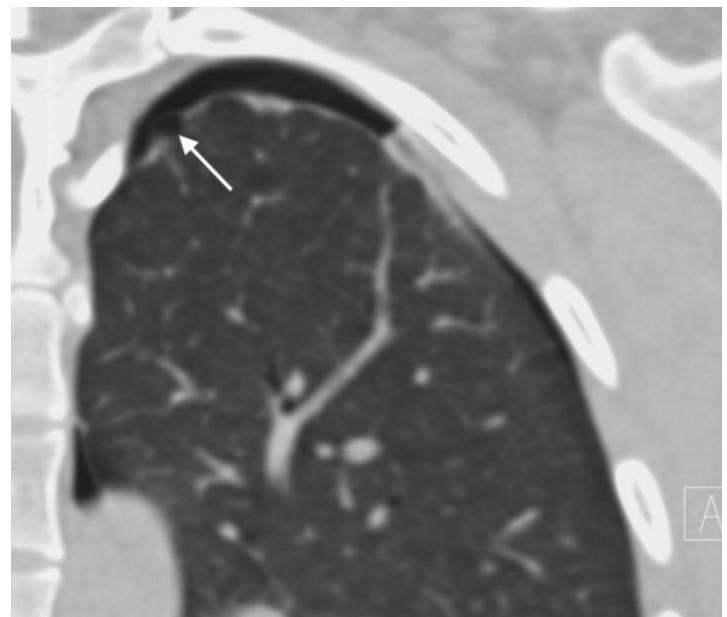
Spontaneous pneumothorax with subpleural emphysematous bullae. The patient is a 27-year-old woman with spontaneous pneumothorax on the left side. CT shows tiny subpleural emphysematous bullae (white arrow) in addition to slight scarring of the apical pleura. These findings may be interpreted as discrete paraseptal emphysema.
